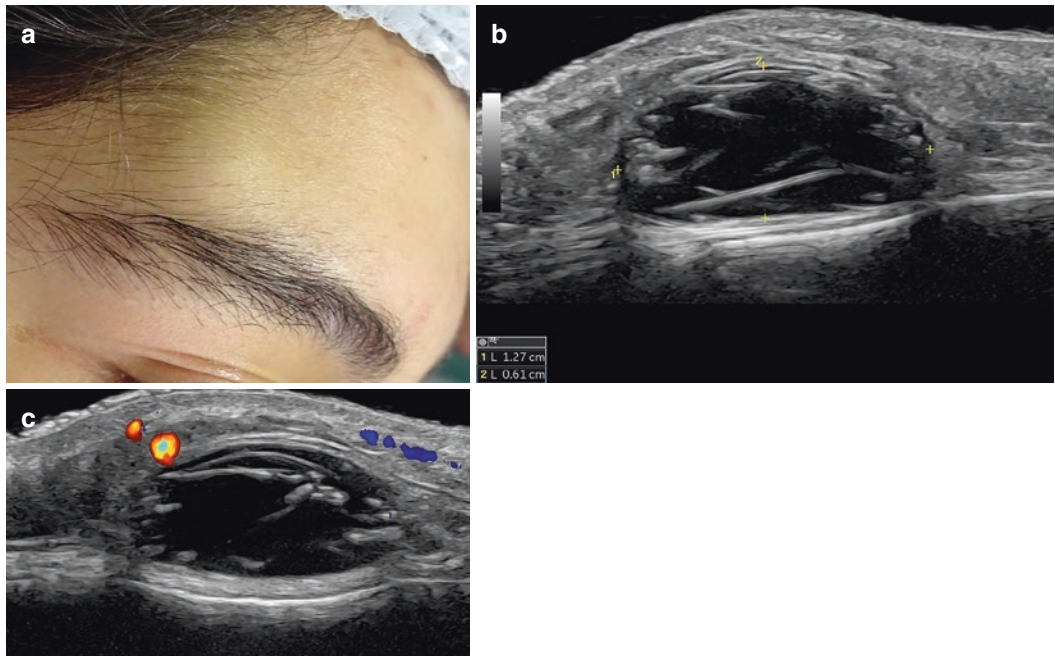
Dermoid cyst. (a) Clinical lesion in the frontal region close to the tail of the eyebrow. (b) Grayscale ultrasound (transverse view) shows oval-shaped, well-defined subaponeurotic structure that contains hyperechoic linear
